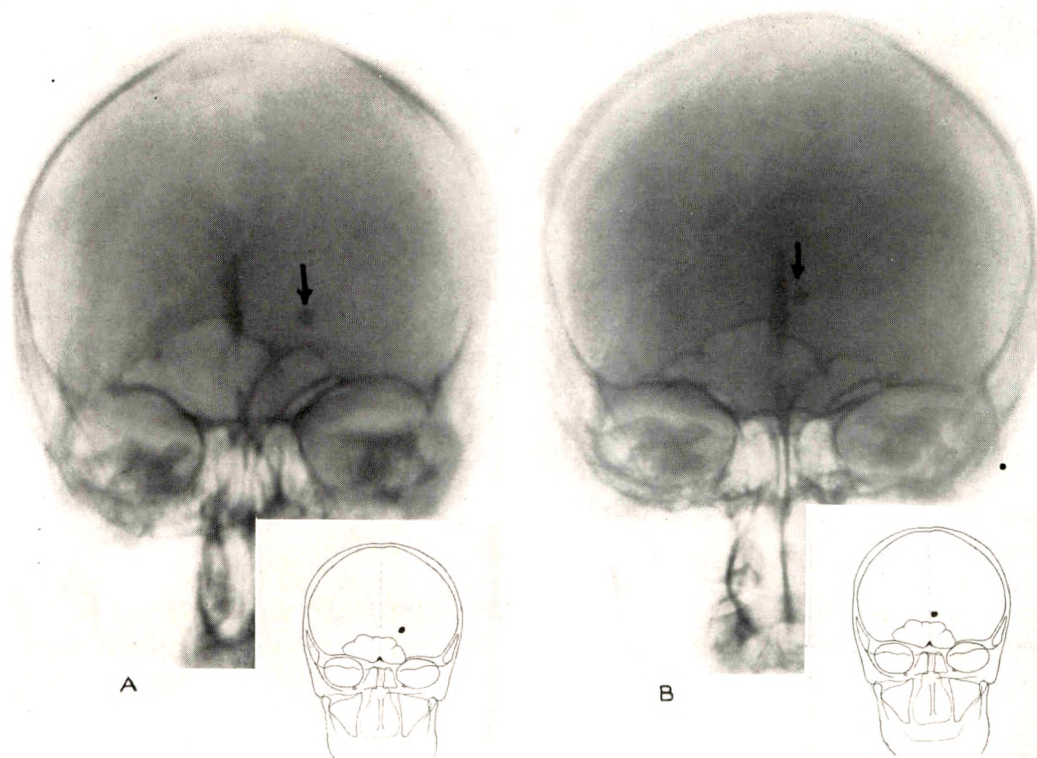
A. Roentgenogram of a skull showing separation of the left lambdoid suture, a fracture extending into the left parietal bone, and displacement of the pineal body to the right indicating the presence of an extensive intracranial hemorrhage on the left side. B. Shows an operative defect in the skull on the left side. A large subdural clot was removed at operation. Following removal of the blood clot the pineal body has returned almost to its normal position in the midline.
